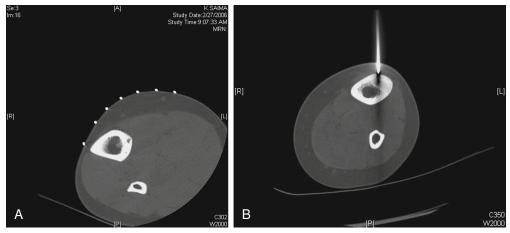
A, Axial computed tomography (CT) scan demonstrating an osteoid osteoma in preparation for B, CT-guided needle biopsy. (From American College of Radiology, Reston, Virginia.)
